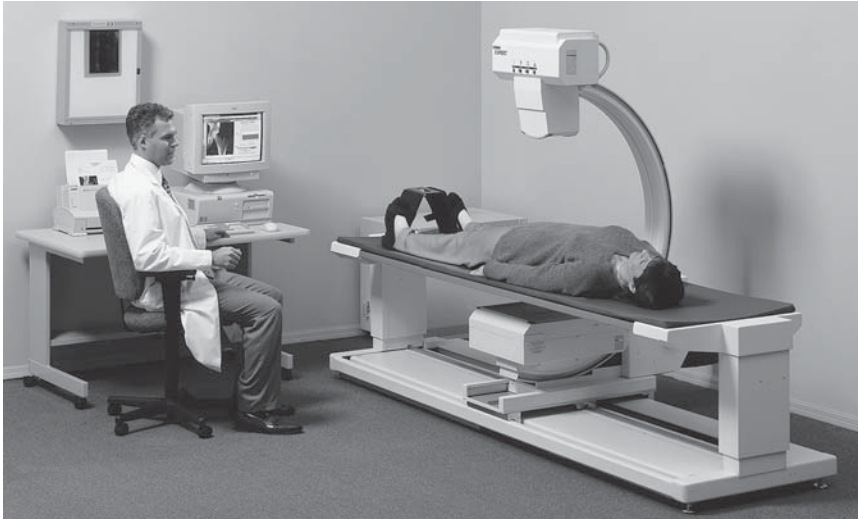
The Lunar Expert®-XL. A central fan-array dual energy X-ray absorptiometer. Photograph courtesy of GE Medical Systems, Madison, WI.
